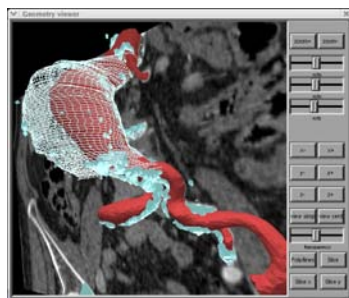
Hybrid visualization of different vascular components (lumen, thrombus, calcium) superimposed to the CT data.
